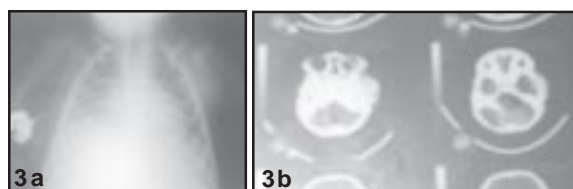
Chest X-ray and CT scan skull showing bony lesions.
